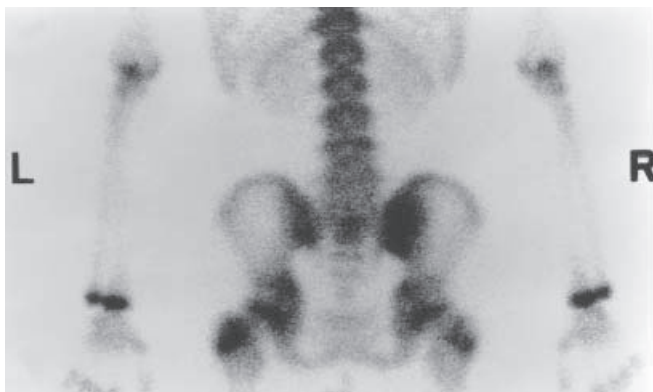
Bone scintigraphy, taken in 1998, revealed increasing uptake in the right sacroiliac joint. *L*, left
